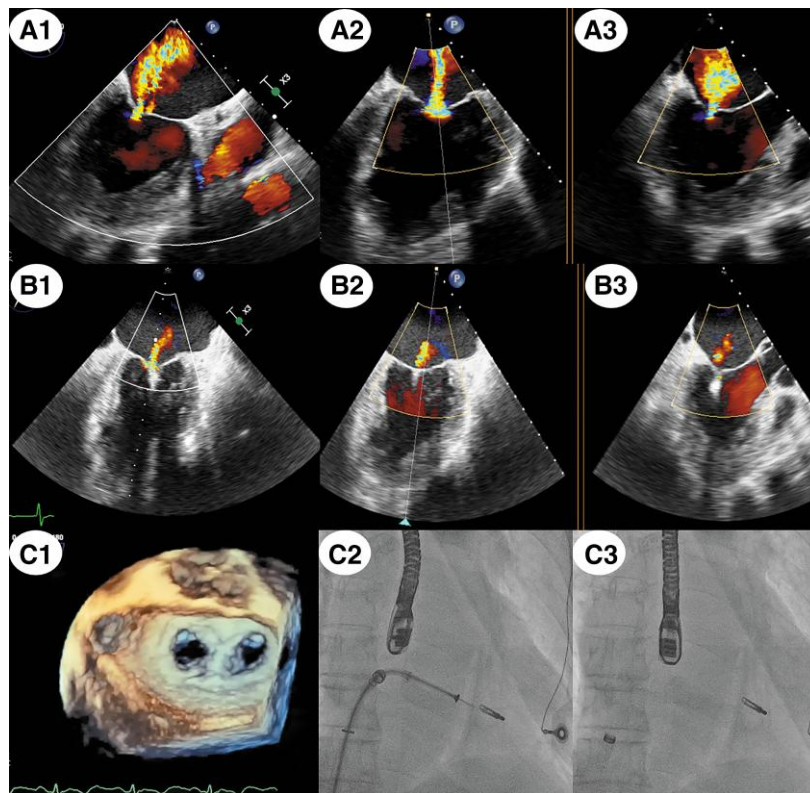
Transoesophageal echocardiography before transcatheter edge-to-edge repair indicated severe mitral regurgitation (A1–A3), while after transcatheter edge-to-edge repair, transoesophageal echocardiography showed a reduction of mitral regurgitation to a trace (B1–B3). 3D transoesophageal echocardiography showed the implanted clip in the A2/P2 region of the mitral valve (C1). X-ray showed one MitraClip was successfully implanted (C2 and C3).
